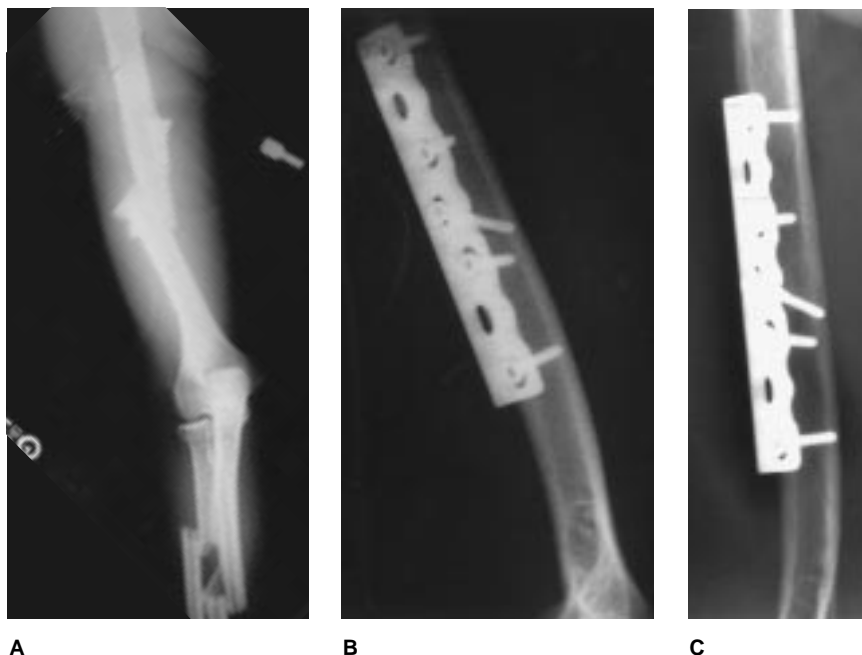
A, Anteroposterior radiograph shows fracture of the ipsilateral humerus and forearm. Anteroposterior (B) and lateral (C) radiographs show healed humeral fracture after fixation with a broad 4.5-mm plate with use of the AO/ASIF technique.
